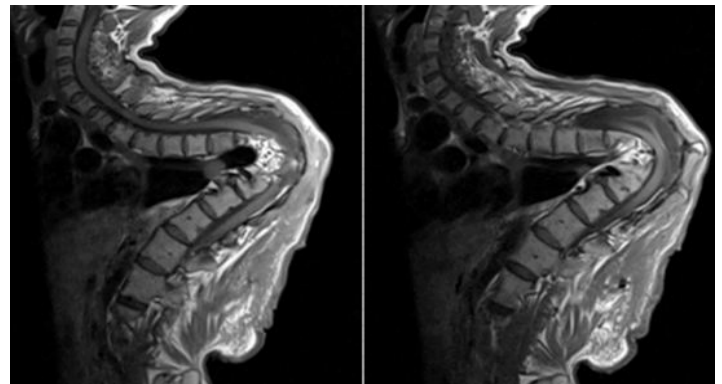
Post-operation MRI showed excision of the tumor with some residual soft tissue tumor.
